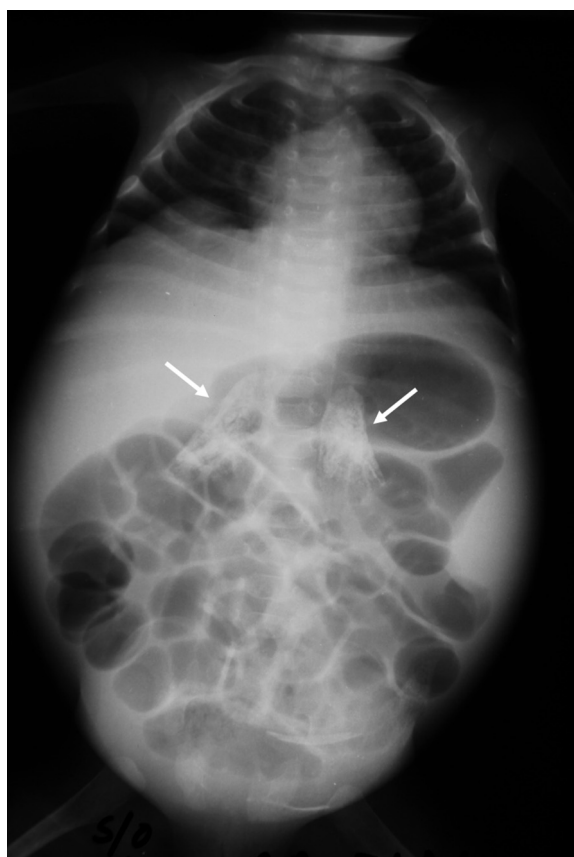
Radiograph of the chest and abdomen reveals a protuberant abdomen with bilaterally enlarged calcified adrenal glands (white arrows).
